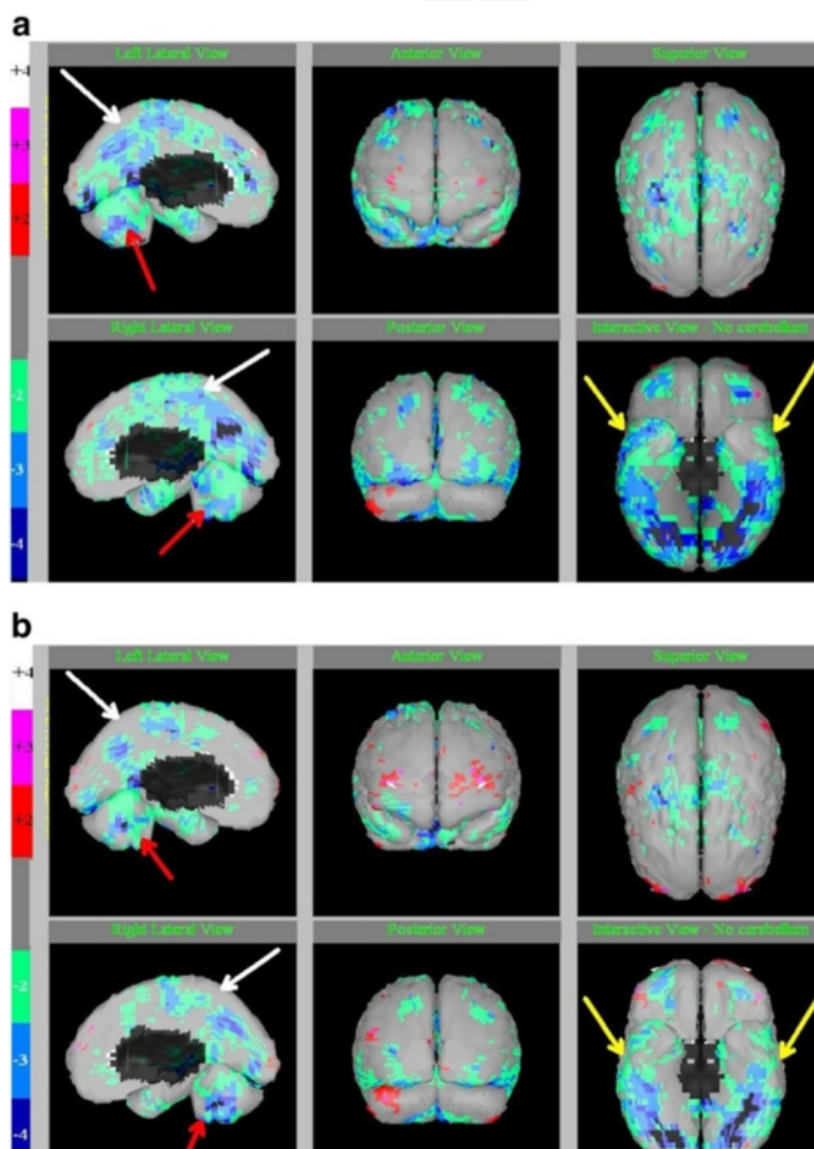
1 SPECT scan images in a 12 year old boy with autism (a) before and (b) after 80 sessions of HBOT at 1.3 atm. Legend: minus 2 (green) to minus 4 (blue) standard deviations indicate the magnitude of regional hypofunctioning (hypoperfusion). White arrows indicate improvement in deeper cortical hypoperfusion patterns. Red arrows on sagittal slices show the midline cerebellum hypoperfusion and improvements after HBOT. Yellow arrows on the “underside” view show the temporal lobe hypoperfusion with improvements after HBOT
